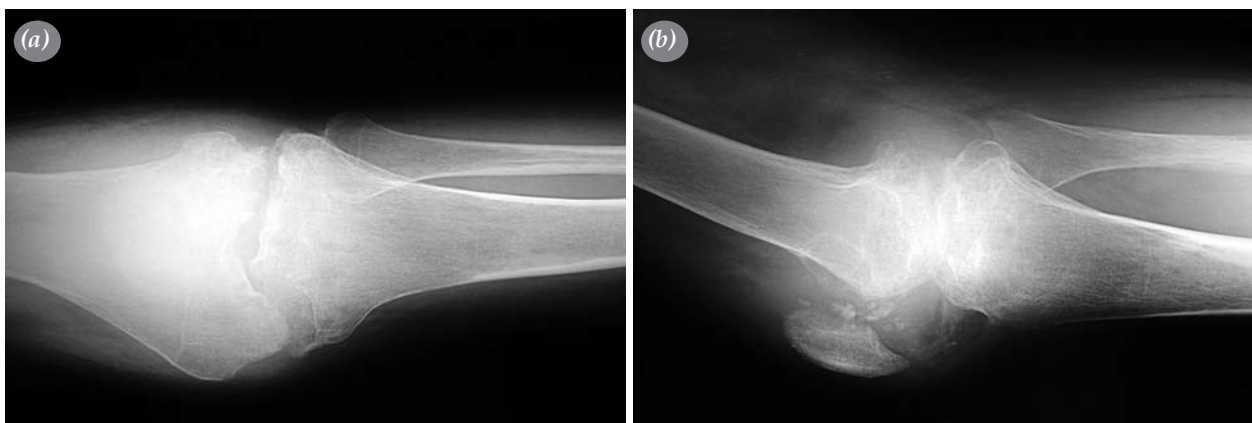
(a) Anteroposterior and (b) Lateral plain radiographs of left knee. High grade degeneration of femoral condyles and tibial plateau is visible, together with joint space narrowing.
